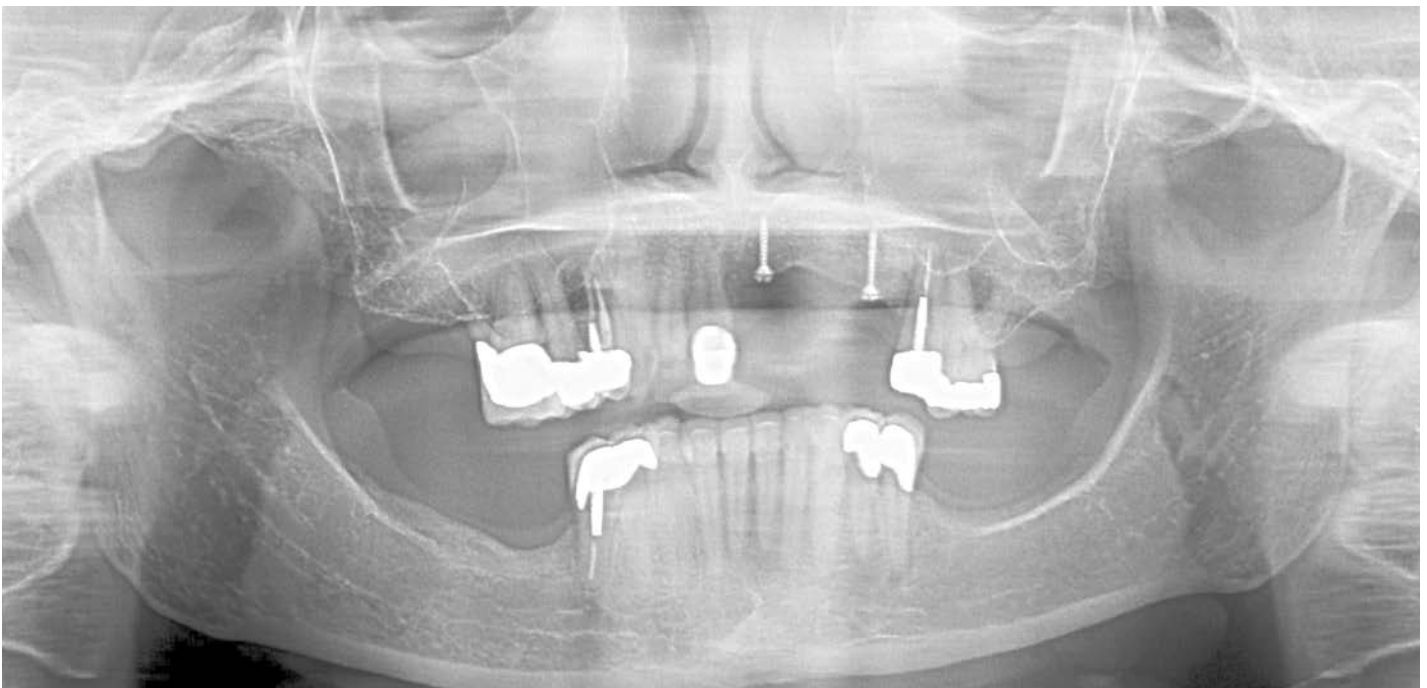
Panoramic radiograph four months after guided bone regeneration surgery in the anterior maxilla. Note the new bone formation to the heads of the tenting screws and the poor condition of the remaining maxillary teeth.
